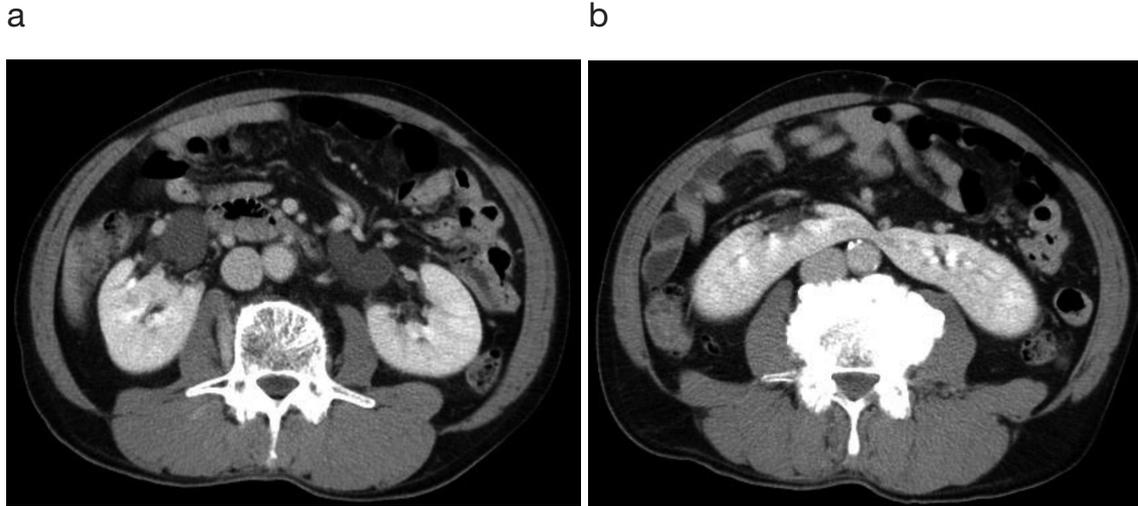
A 65-year-old man with expansion of both sides of renal pelvis. (a, b) Axial computed tomographic images with contrast enhancement show bilateral dilation of the renal pelvis (right, 23 mm; left, 24 mm) of unknown cause.
